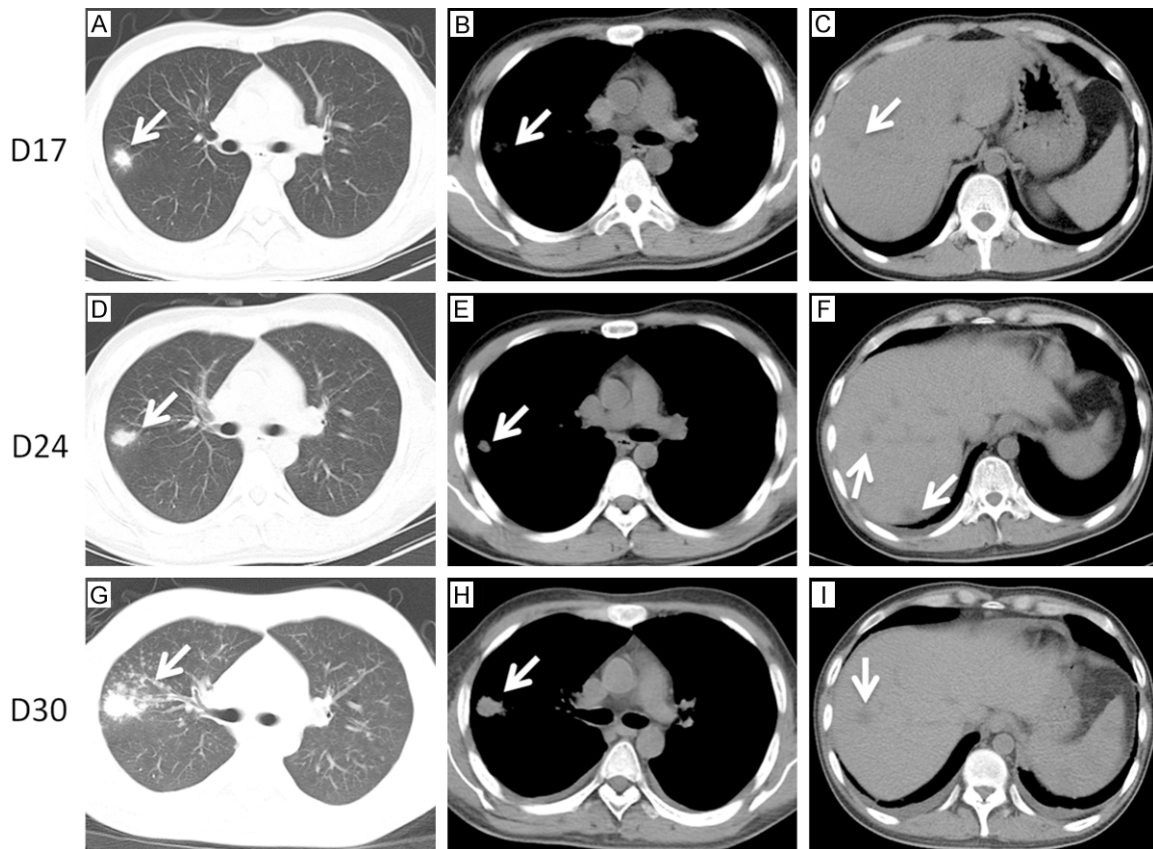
Infiltration and nodular lesions in lungs and liver detected by CT scans.
